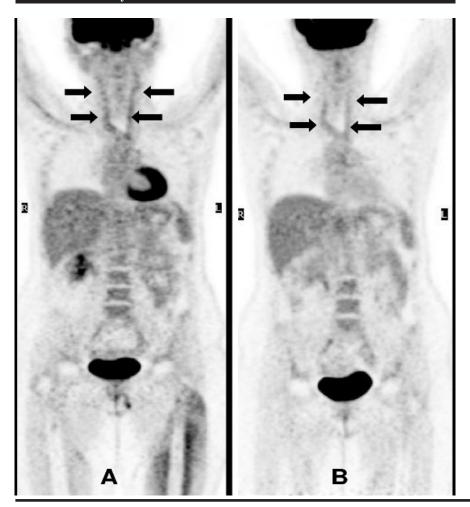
FDG PET: Coronal image before (A) and after (B) tocilizumab.
